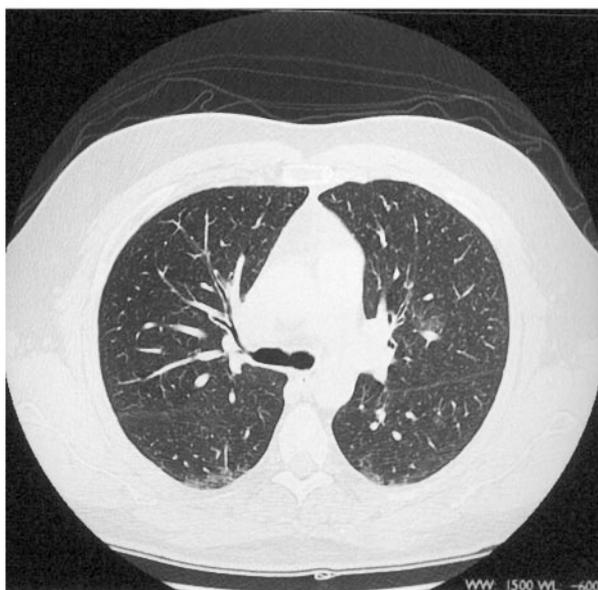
CT scan of the chest after steroid therapy showed almost complete resolution of the ground-glass opacities.
